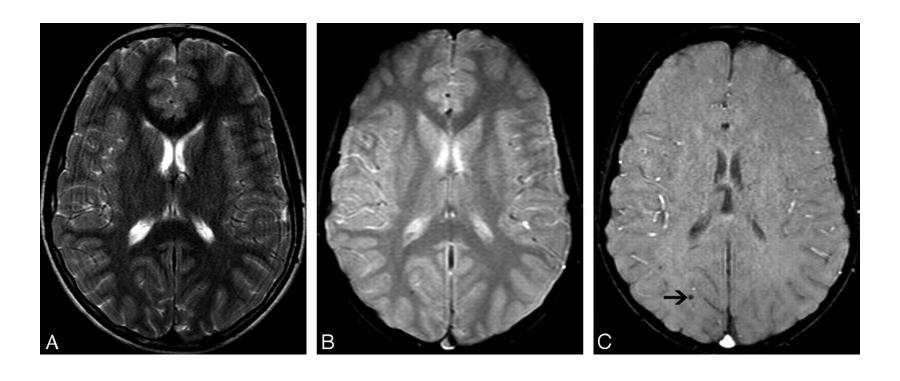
A 46-year-old male patient with familial CCM. (*A*), Axial T2-weighted FSE image shows no significant abnormalities. (*B*) Axial T2-weighted GRE image demonstrates a small extinction on the right parietal region, though it is larger on SWI (Susceptibility weighted imaging, type IV lesion) (*C*, *arrow*).
